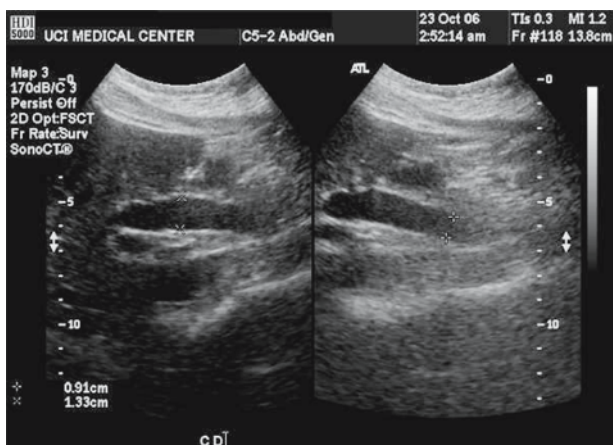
Right upper quadrant abdominal ultrasound examination showing a dilated common bile duct.
